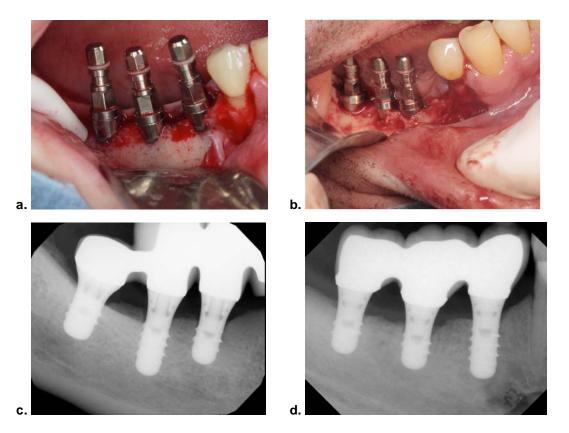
Short implants placed in the posterior mandible. 4.1. a. and 4.1.b. Surgical site preparation for three implants. 4.1.c. and 4.1.d. Periapical radiograph of 3 short implants placed and splinted.
